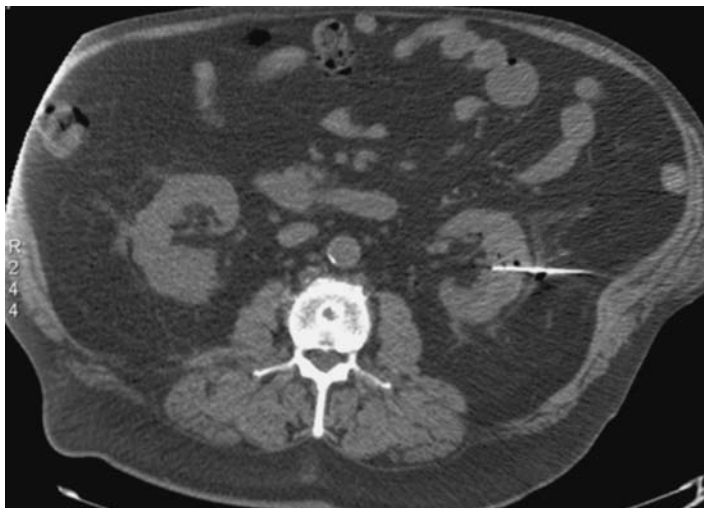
Percutaneous biopsy in a 65-year-old man. Non-contrast axial CT demonstrates pockets of air in the biopsy tracts and a minor degree of perinephric stranding after sampling of a small left renal mass using landmarks for guidance.
